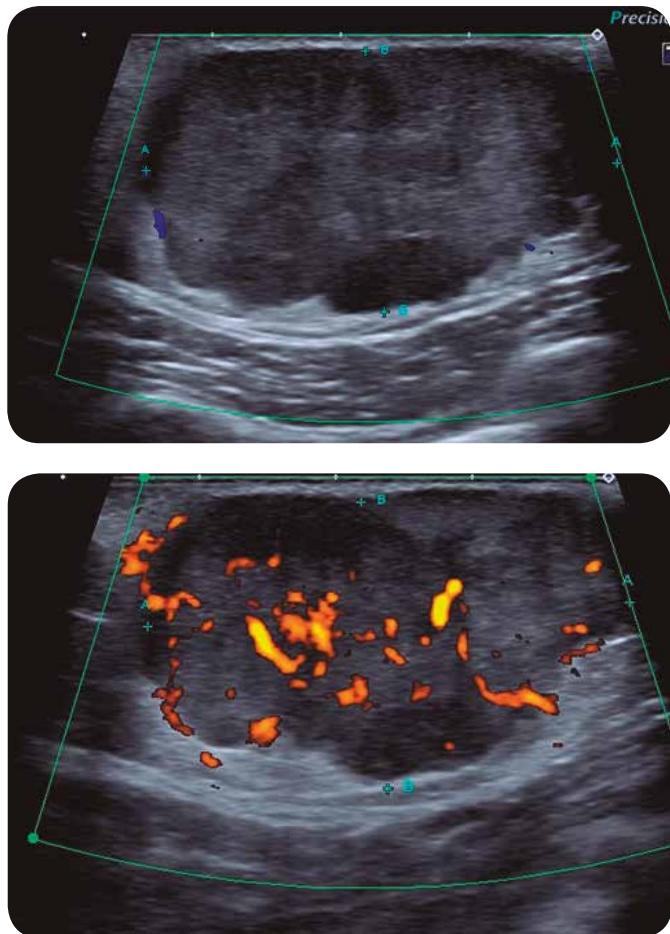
Ultrasound: nodular image, ovoid, with macrolobulations, hypoechoic, homogeneous, circumscribed, vascularized, without calcifications, located in the retroareolar region of the left breast,  $3 \times 7$  cm in its major diameters.
